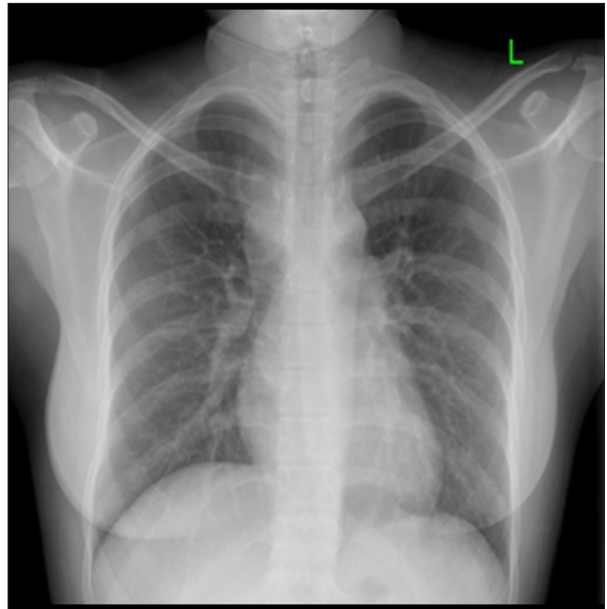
Chest radiograph (posteroanterior view). Chest X-ray posteroanterior view showing normal study.
